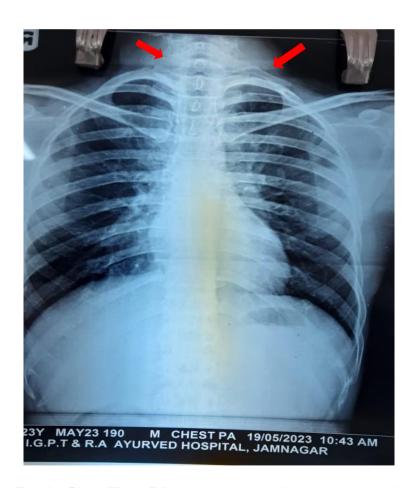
Chest X-ray PA view showing bilateral cervical rib
